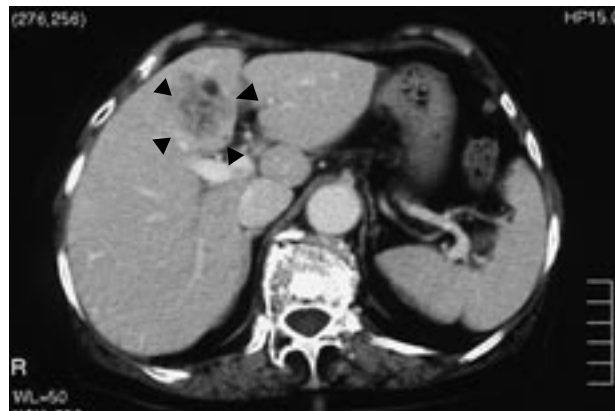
An enhanced computed tomography (CT) scan shows a 5-cm space occupying in S5 region of the liver.
